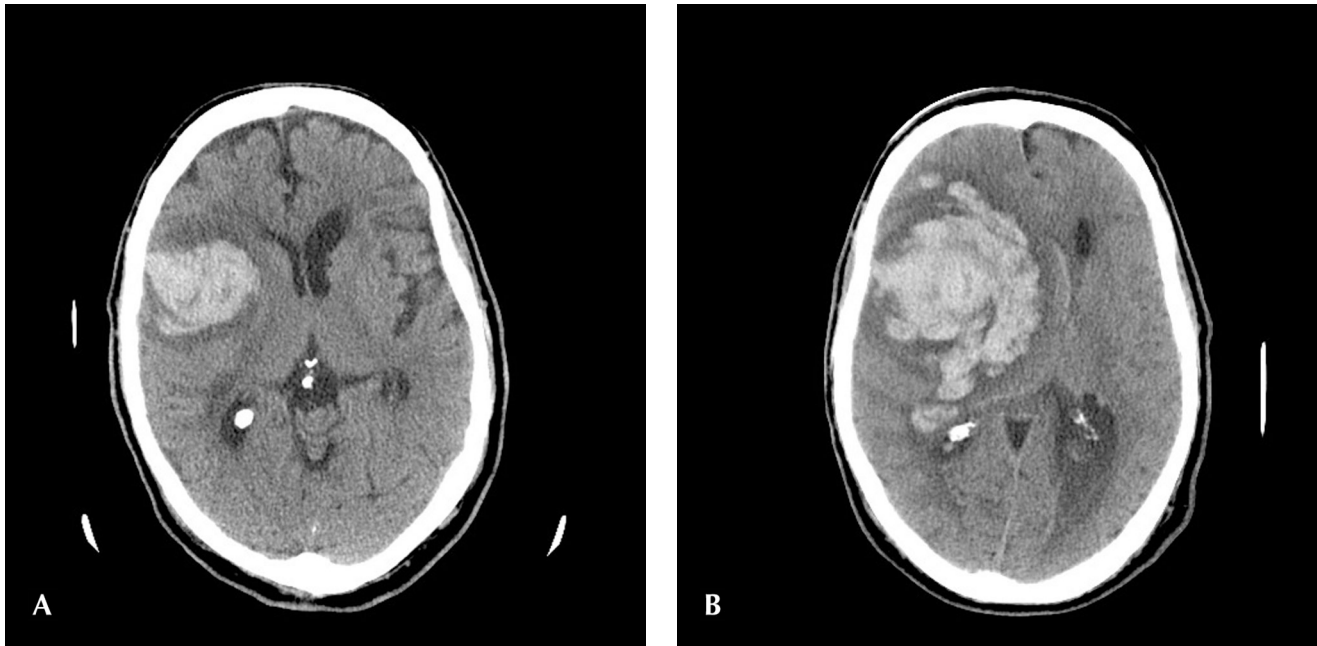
A, An 81-year-old patient with acute intracerebral hemorrhage (ICH). ICH volume is calculated by the formula $ABC/2$ [23]. A and B are perpendicular diameters of the hematoma on the CT slice with maximal hematoma size. The vertical diameter, C, is obtained by counting the number of vertical slices that display the hematoma (10, not shown) multiplied by slice thickness (0.5 cm/slice). The values obtained for A (4 cm), B (4.5 cm), and C (5 cm) are then multiplied together and divided by 2. Hematoma volume by this method in this case is 45 cm^3 . B, Hematoma enlargement in this patient's case (1 hour and 42 minutes after the first CT) is approximately 390% enlarged ($6.7 \text{ cm} \times 9.6 \times 14 \text{ slices at } 0.5 \text{ cm/slice}$) to 227 cm^3 . Hematoma enlargement can be calculated as percentage of change in ICH volume by the formula $(F - I)/I \cdot 100$, in which F represents later CT-measured ICH volume (cm^3) and I represents the earlier CT-measured ICH volume [24, Class I].
